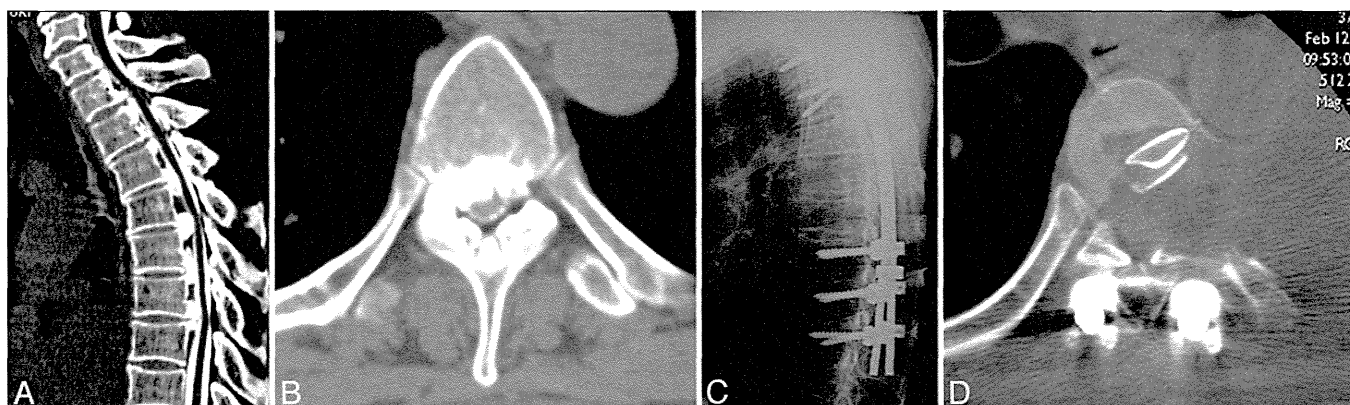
Images obtained in a 49-year-old man with the continuous waveform type of OPLL. The patient was not ambulatory prior to surgery because of severe myelopathy. He underwent posterior decompression and fusion using spinal instrumentation. Since his neurological status remained almost the same as before surgery, he underwent anterior decompression and fusion via a transpleural approach 4 weeks after the posterior surgery. He had gradual neurological improvement and was able to resume walking with bilateral crutches 1 year after surgery. A: Sagittal reconstructed CT scan. B: Axial CT scan at the T-6 level. C: Lateral radiograph obtained after posterior decompression and fusion. D: A CT scan at the T-6 level obtained after anterior decompression and fusion.
